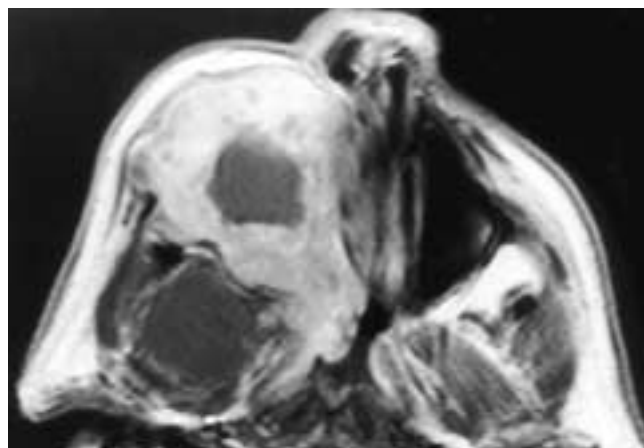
Axial T1-weighted, contrast-enhanced MR image shows a large, destructive tumor in the right maxillary sinus that has invaded the overlying skin, the nasal fossa, the infratemporal fossa, and the central skull base. This appearance is similar to that of a squamous cell carcinoma; however, this patient had an adenoidcystic carcinoma.
